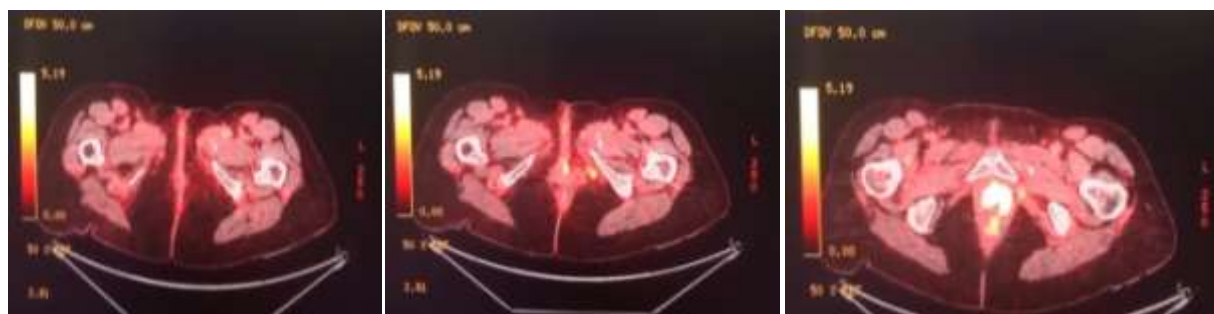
Follow-up PET-CT scan performed three months after completion of induction chemotherapy and concurrent chemoradiotherapy.
